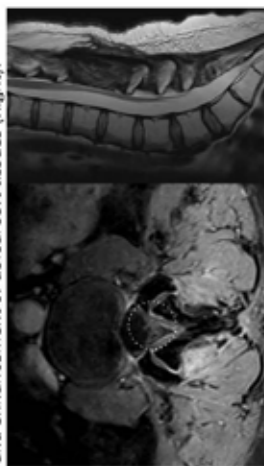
Axial lumbar MRI showing treatment-related enhancement of nerve roots at L1 (Left); Sagittal thoracolumbar MRI showing L1 laminectomy and enhancement of dorsal soft tissues (Right).
